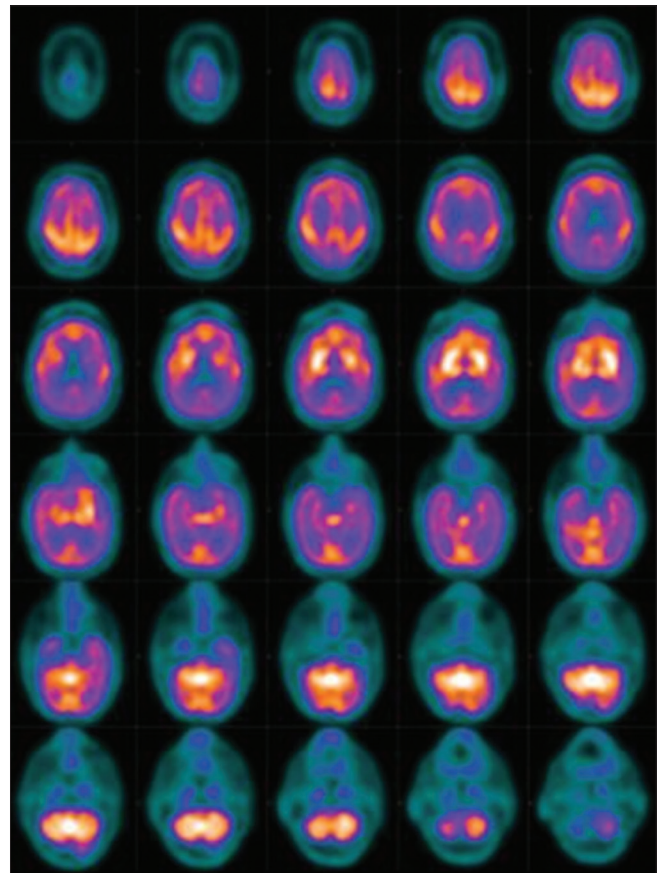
Axial 18F-FDG PET images showing moderate-to-severe hypometabolism in the bilateral parieto-temporal and bilateral occipital cortices including the primary visual cortices with associated hypermetabolism in the bilateral sensorimotor cortices, bilateral basal ganglia, thalami, brain stem, and bilateral cerebellar hemispheres
